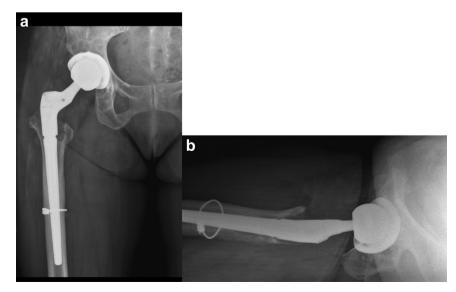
Post-operative radiograph: post-operative anteroposterior (a) and lateral (b) views of the right hip with revision of femoral and acetabular components.
